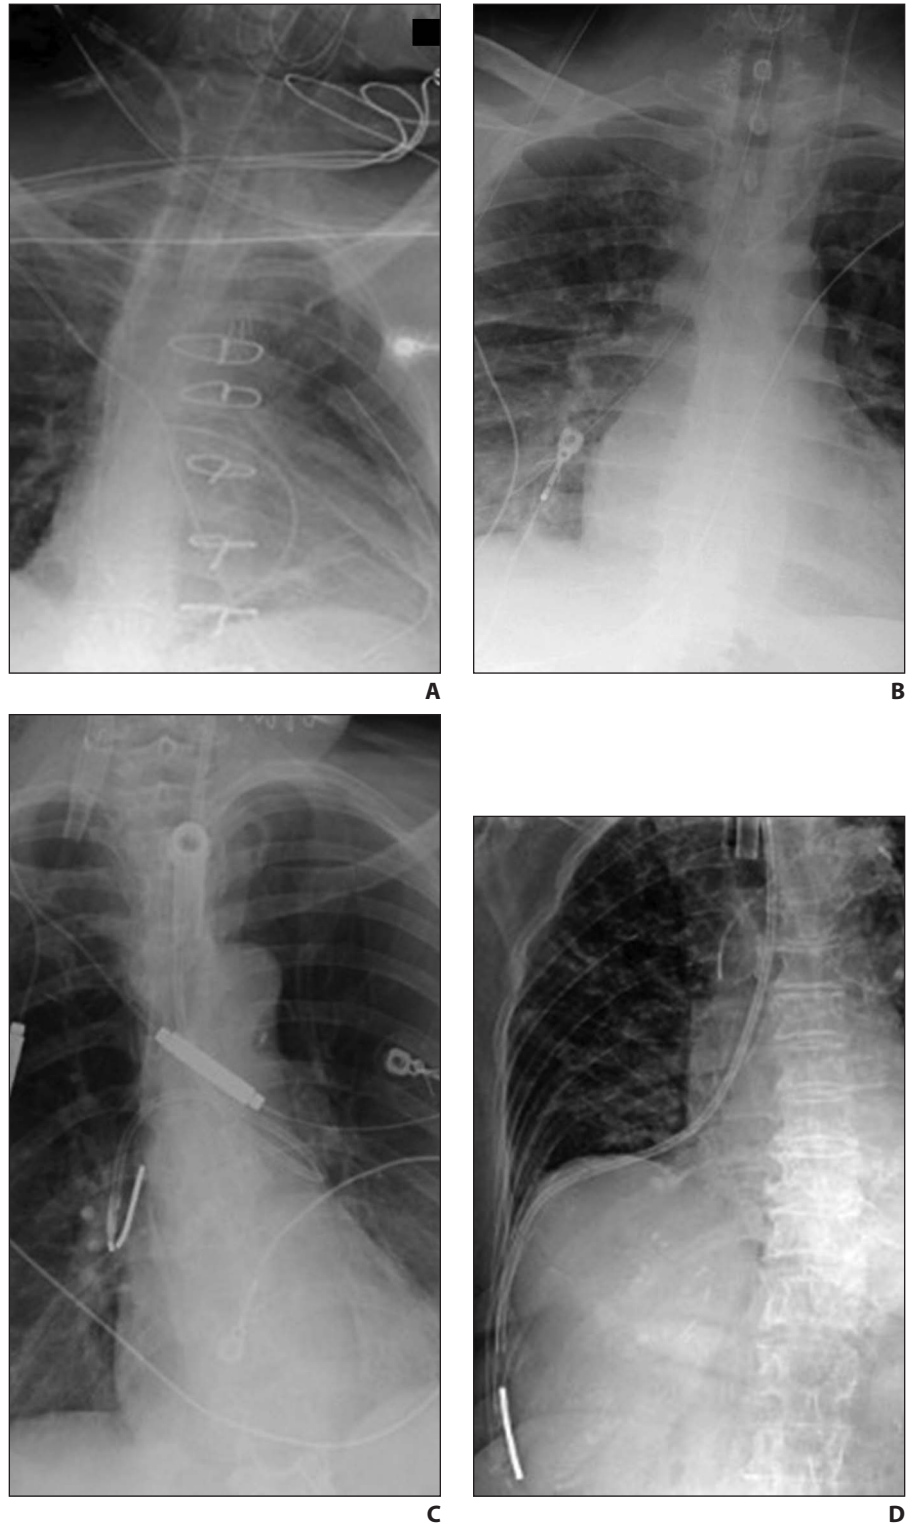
Malpositioned nasogastric and gastroenteric feeding tube deployments, as seen on coned-down anteroposterior portable chest radiographs of four patients.
